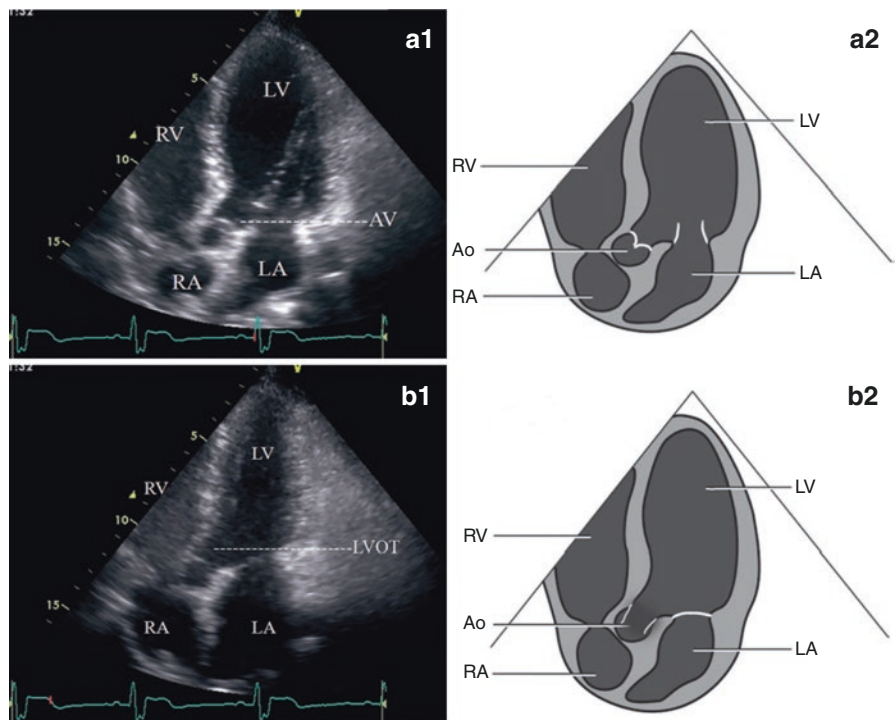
Apical five chamber view (a) Diastole (b) Systole RV Right ventricle, Ao Aorta, RA Right atrium, LA Left atrium, LV Left ventricle (Reprinted with permission from He [61], p. 93)
